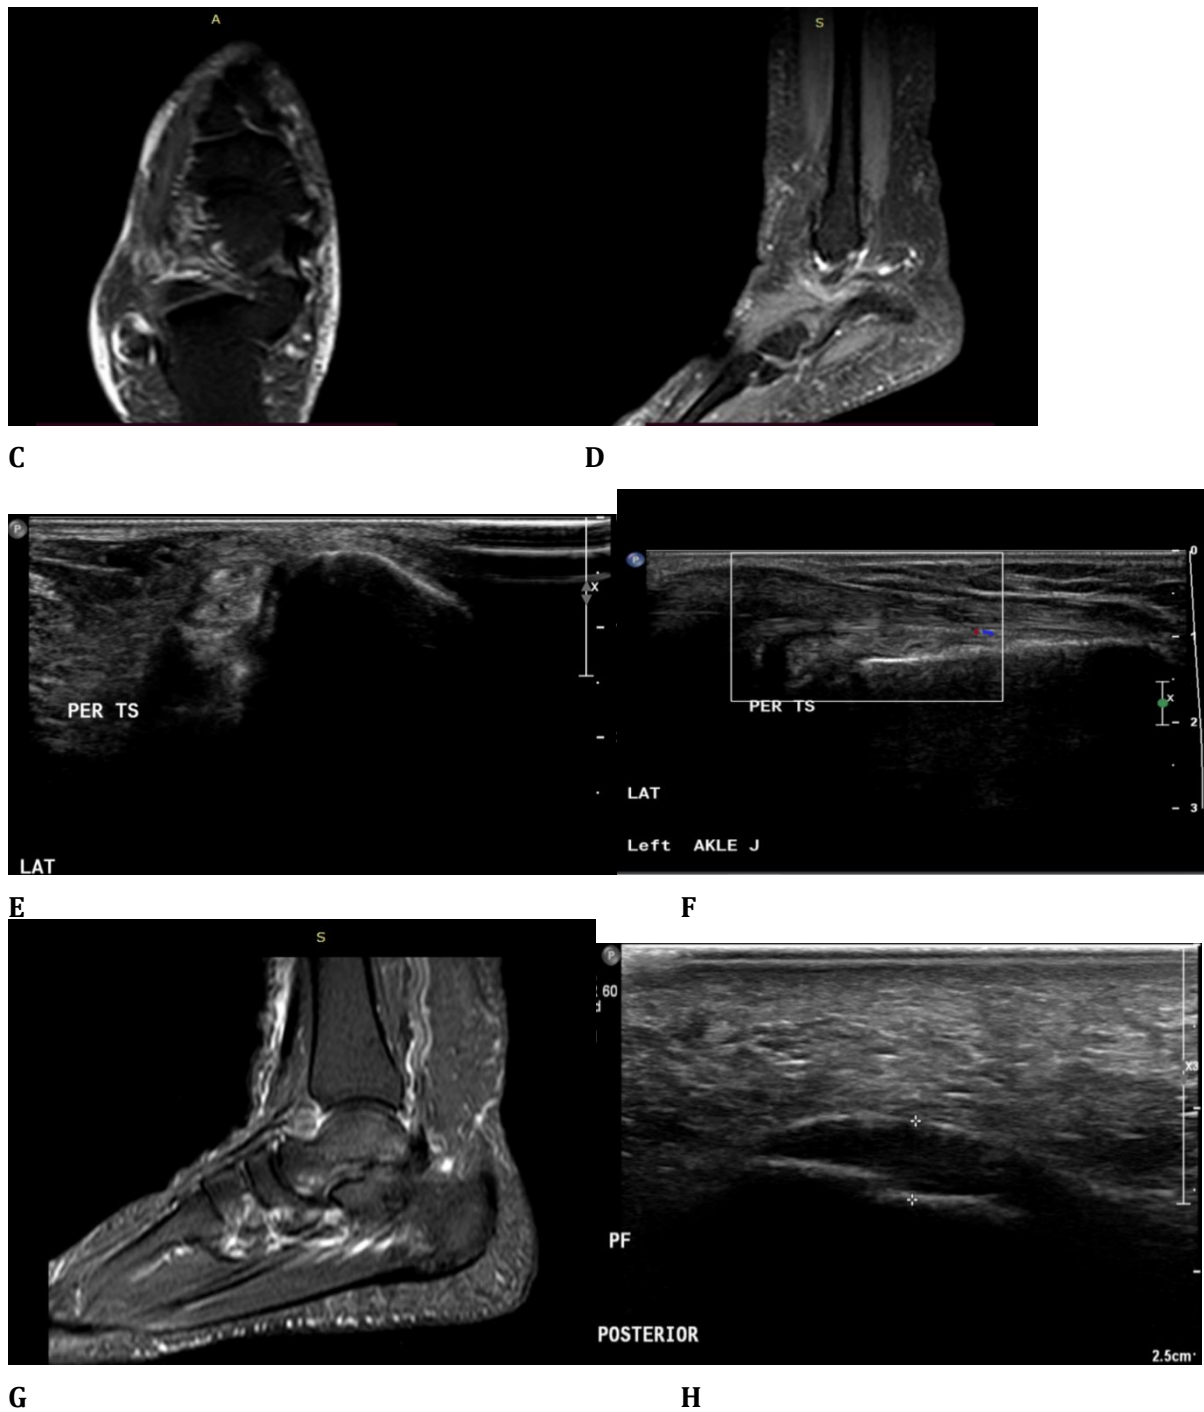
56 yrs old Female patient with rheumatoid arthritis complaining of morning stiffness and limitation of movements of her ankle. 2-A. Ultrasound image (transverse view) showing mild joint effusion of anterior recess. B. STIR MRI (coronal view) image viewing mild joint effusion. C. & D. STIR MRI (coronal & sagittal respectively views) showing mild tenosynovitis of peroneal tendons. E. & F. Ultrasound image (transvers & longitudinal views) exhibit a minor case of tenosynovitis in the peroneal tendons. G. PD weighted MRI (sagittal views) showing bony calcaneal spur & mild plantar fasciitis. H. Ultrasound image (longitudinal view) showing mild plantar fasciitis.
